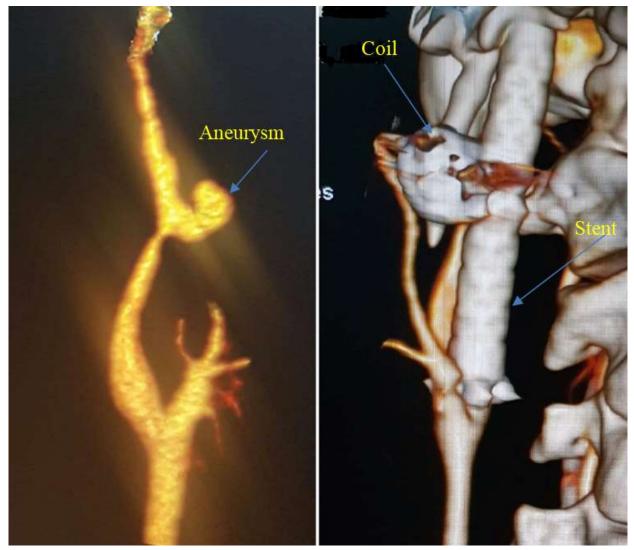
(left). Right Internal carotid artery Aneurysm with Tortuity as seen on CT angiography. (Right) Intraoperative repair with coiling and placement of a covered stent graft.
